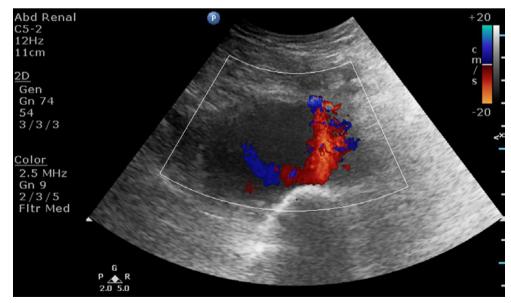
Color Doppler ultrasound longitudinal scan of the left upper thigh reveals bidirectonal flow inside the aforementioned lesion typical of aneurysm/pseudoaneurysm (the yin-yang sign). It also depicts the feeding artery (a branch of the profunda femoral artery (pr.FA)).
